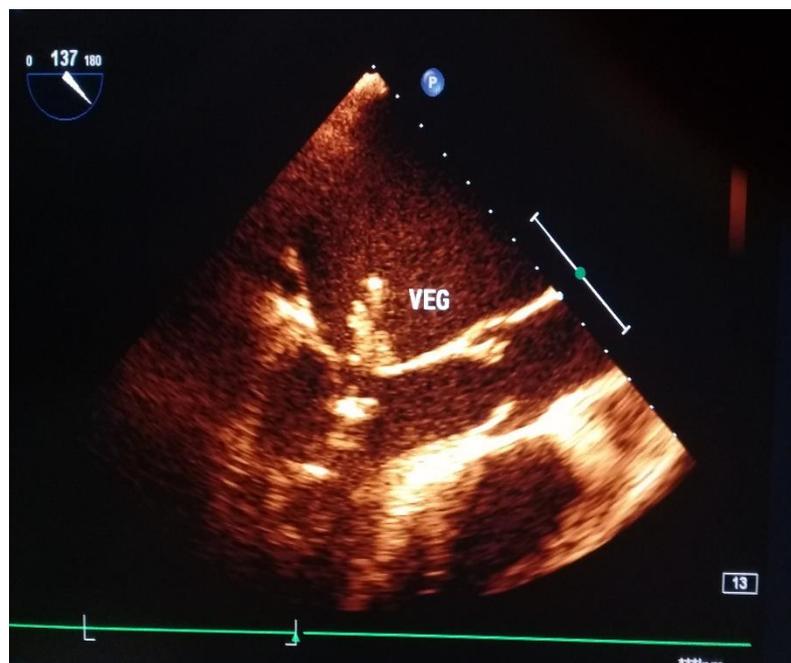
Cluster-shaped vegetation of the mitral valve in the transoesophageal echocardiogram (TEE)
